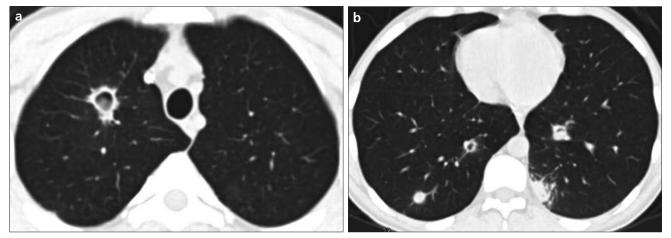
a, b. Axial CT images (a, b) showing bilateral cavitary nodules with air crescent sign in a 33-year-old neutropenic patient with acute lymphoblastic leukemia. Invasive aspergillosis was diagnosed on the basis of galactomannan positivity.
